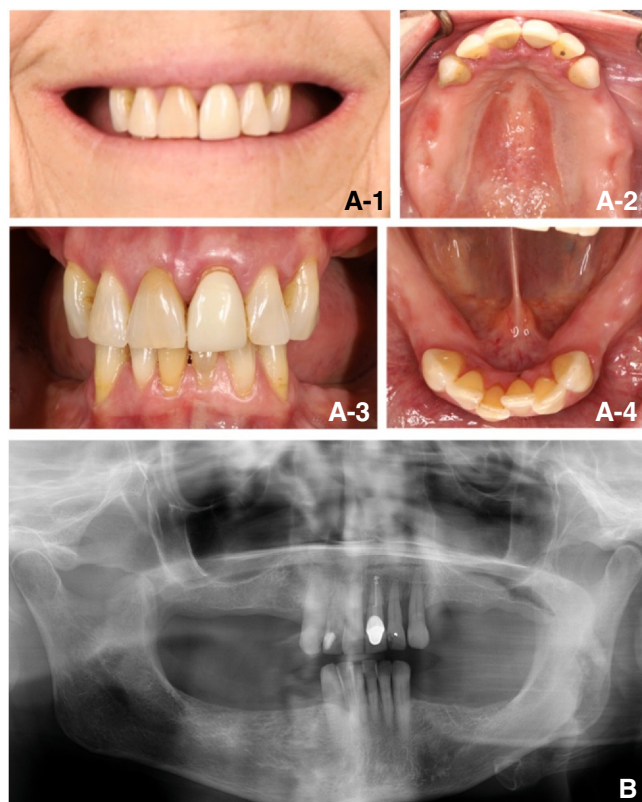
A, Preoperative extraoral and intraoral photographs. B, Preoperative panoramic radiograph.
